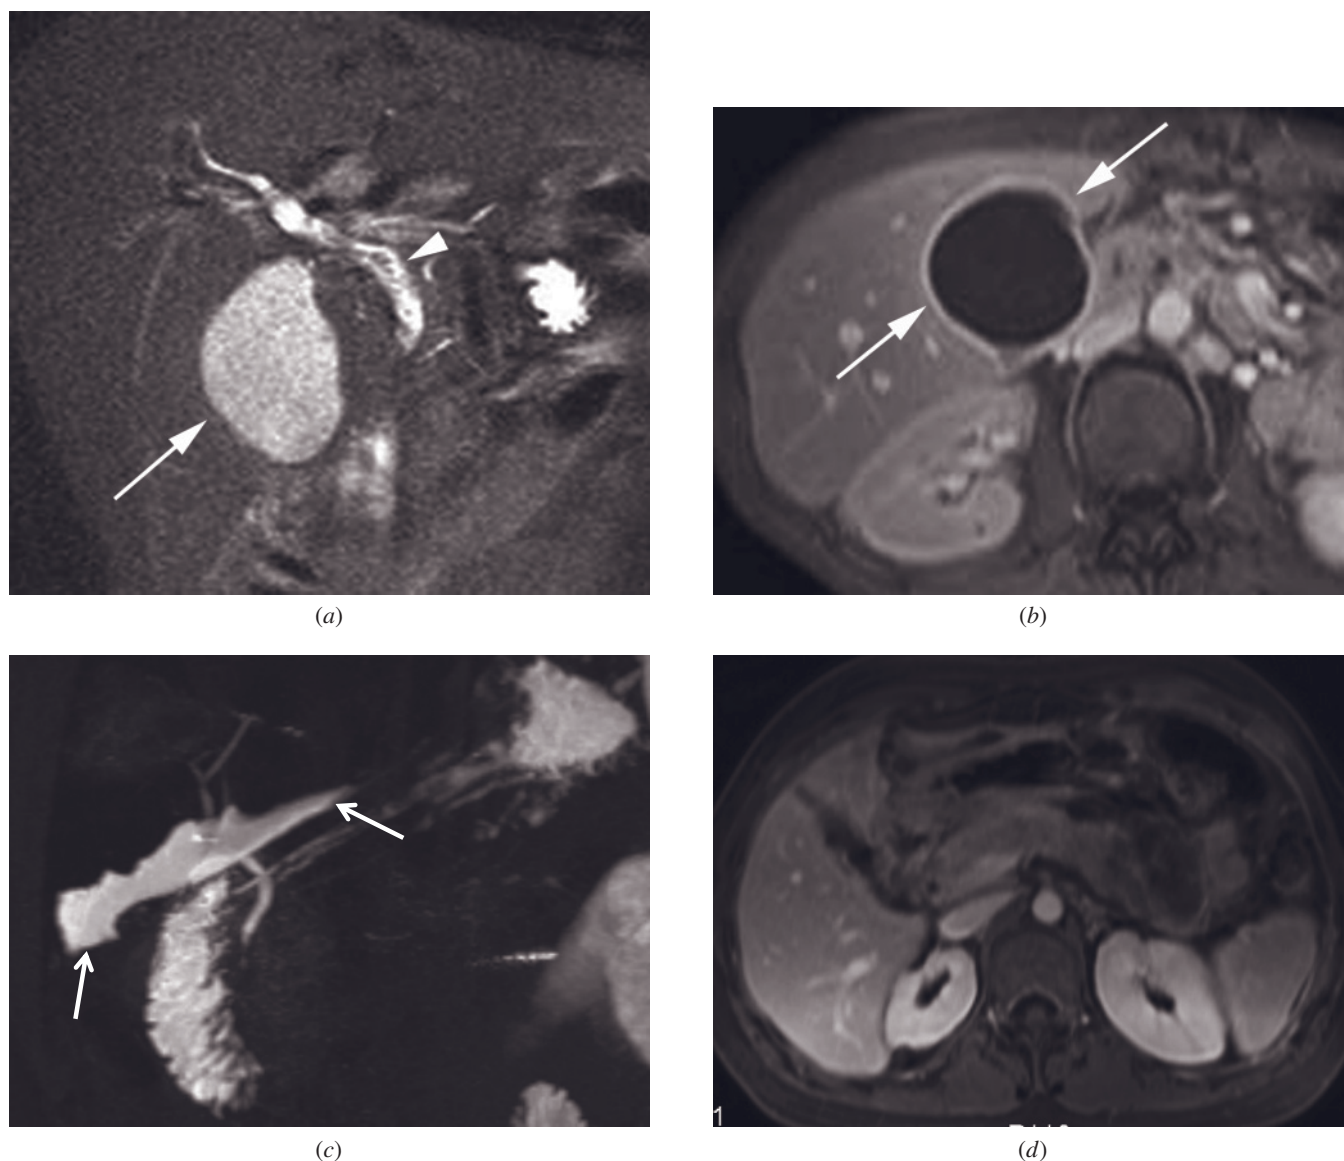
Biloma. T2-weighted fat-suppressed single-shot echo-train spin-echo (*a*) and T1-weighted 2-min postgadolinium fat-suppressed GE (*b*) images in a 44-yr-old woman with a history of open cholecystectomy and persistent right upper quadrant pain. A fluid collection (arrows, *a*, *b*) is depicted in the gallbladder bed, resembling a gallbladder. The fluid collection (biloma) has an enhancing wall (arrows, *b*) caused by an inflammatory reaction of the surrounding peritoneum. The common bile duct (arrowhead, *a*) shows inhomogeneous internal signal caused by a T-tube drain.
